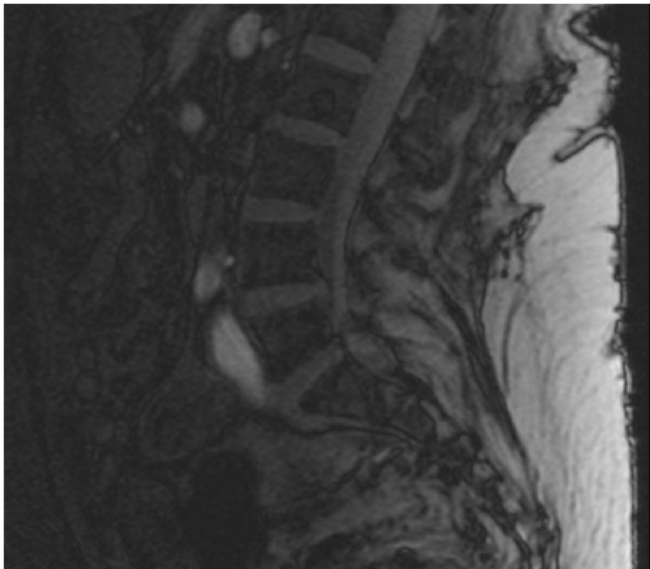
T-2 weighted MRI of the lumbar spine with enhancement in the L4-S1 region indicating early phlegmon.
